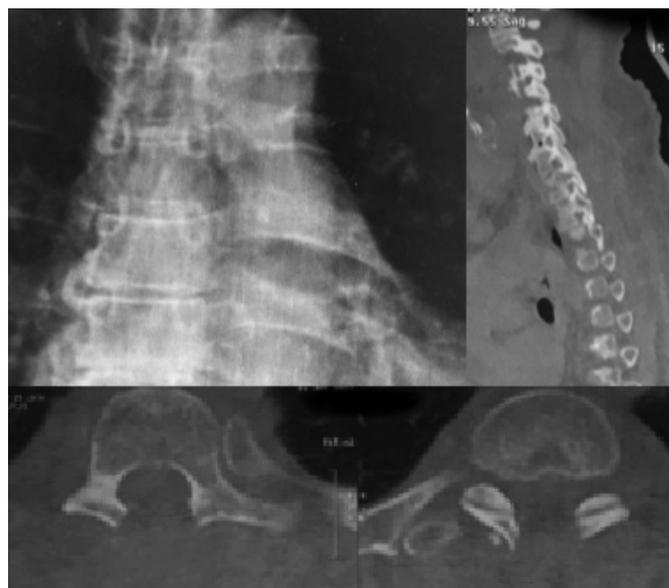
Spine X-ray and CT depicting laminectomy on T1-T2. Ligamentum flavum resection with ossification, evidence of spinal canal enlarged and with no stenosis in this segment.
